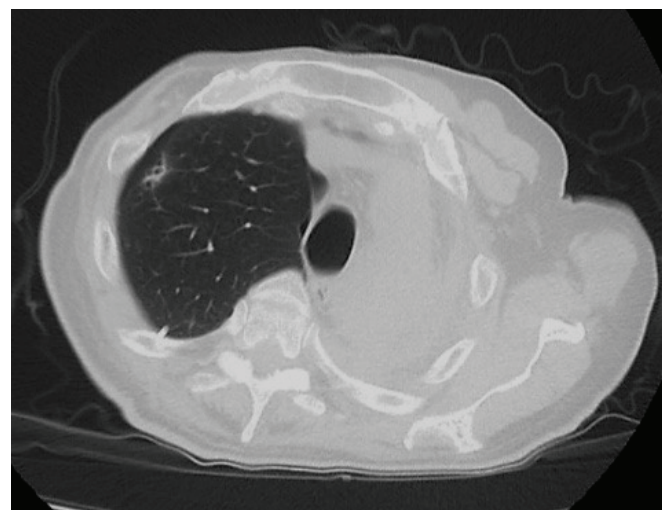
Chest CT performed due to persistent air leak, showing a peripheral metastatic nodule in the right upper lobe.
